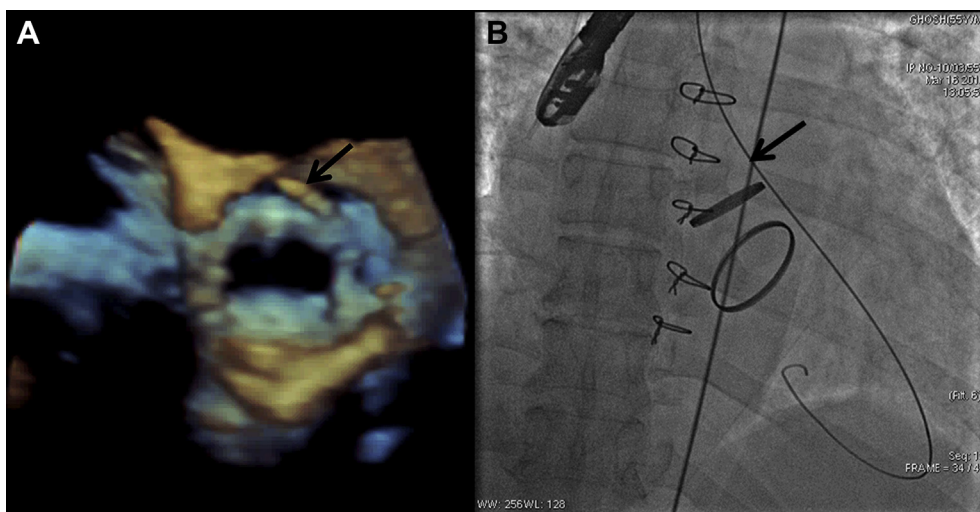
Initial guide wire should cross only the paravalvular leak and not the lumen of the valve. Live three dimensional transesophageal echocardiogram (A) and fluoroscopy in an appropriate projection (B) confirm that the guide wire (arrow) has passed only through the paravalvular leak and not the valve orifice.
